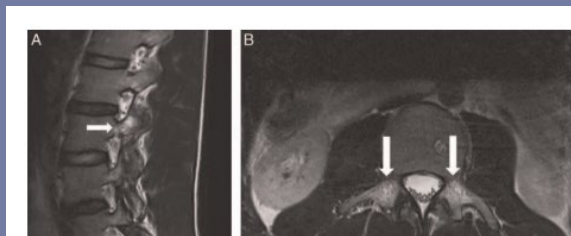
T2-weighted sagittal MRI sequence showing edema surrounding L3 pars fracture (A, sagittal view and B, an axial view), which is tracking along the adjacent soft tissues and chronic L4-L5 pars defect with fluid in the adjacent facet joint but with no surrounding edema. Arrows indicate focus on the spot of the vertebrae where the fracture is located.
